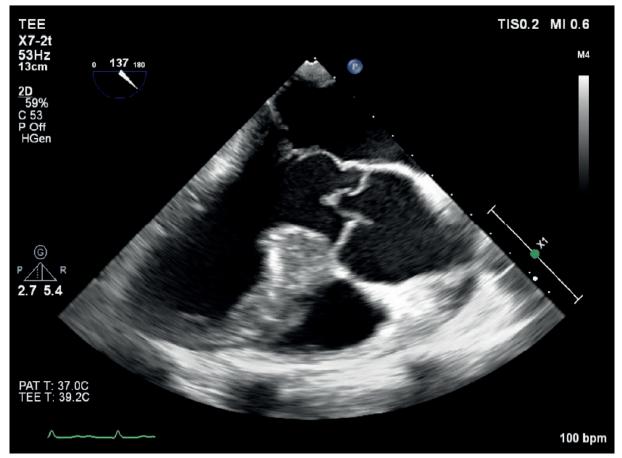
Transesophageal echocardiography showing vegetation on and a prolaps of the non-coronary cusp.
